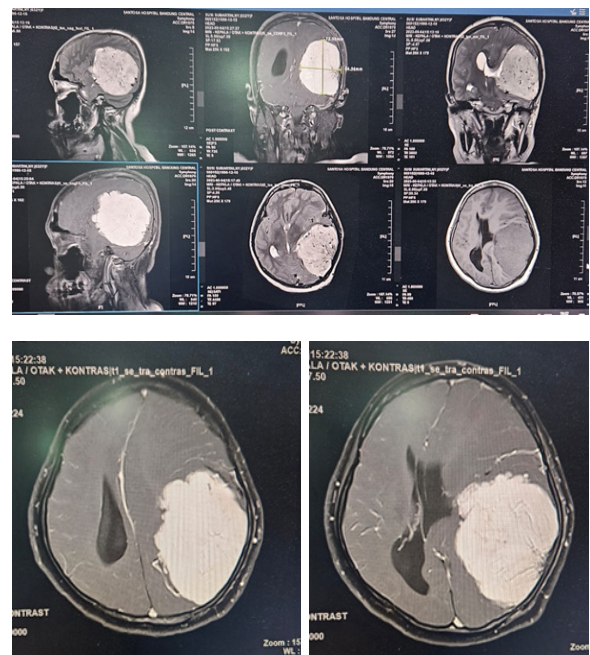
MRI Test Result
